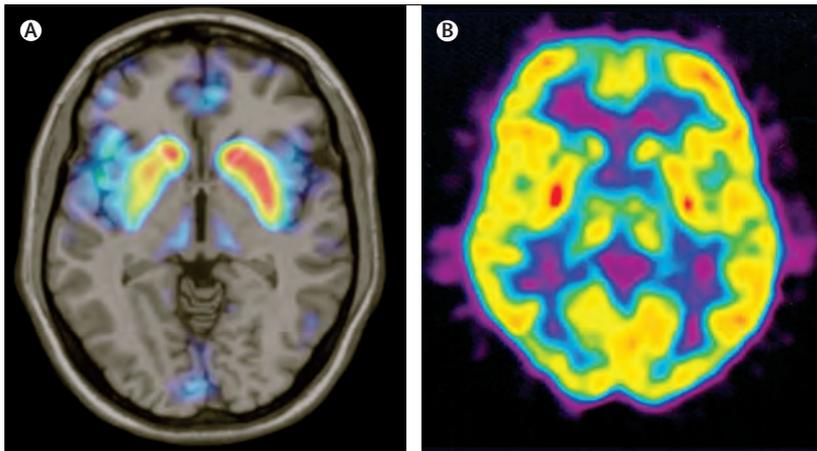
MRI and PET of the brain from a patient with Parkinson's disease confined to the right arm at the time of diagnosis
